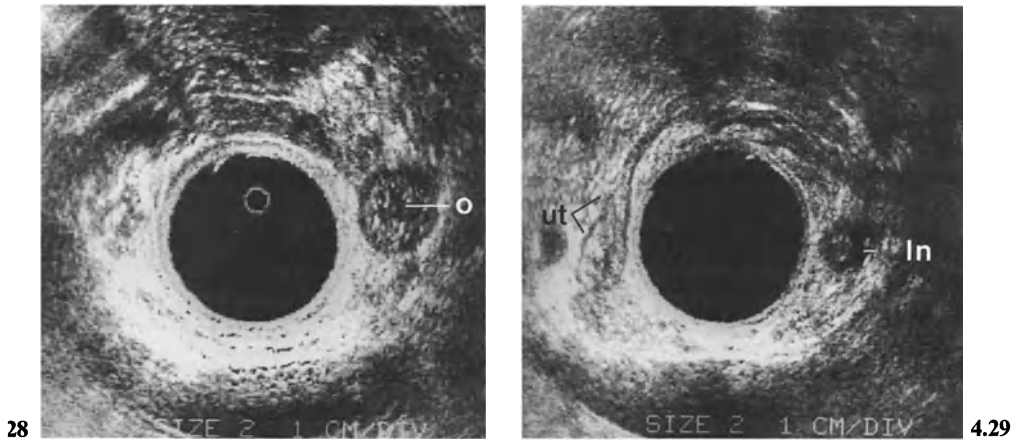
Sonogram of the left ovary (*o*) in a 50-year-old patient. Diameter of ovary: 2 cm
